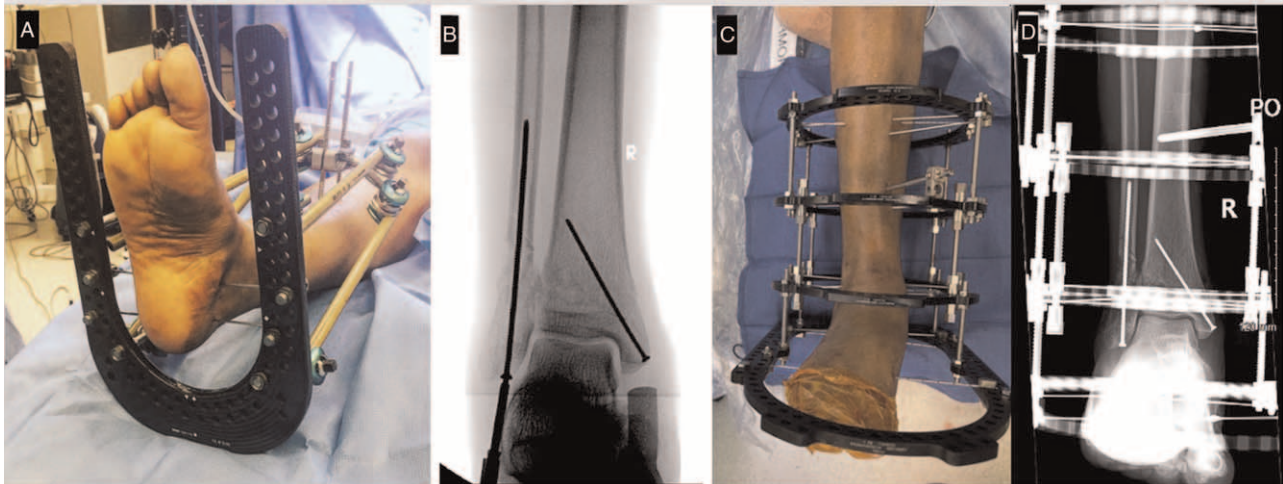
Technique. (A) “Hybrid” uniplanar external fixator. (B) Limited internal fixation with low profile implants. (C) Clinical photo of limb alignment in the multiplanar external fixator. (D) AP x-ray of final fixation construct.
